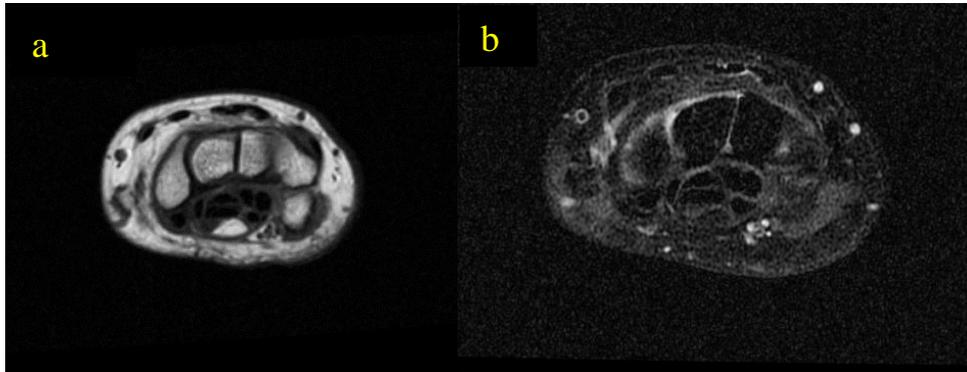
T1-weighted axial MRI image showing an occupying-space lesion with hyperintense in the carpal tunnel (a). T2-weighted axial MRI image showing an occupying-space lesion with hypointense in the carpal tunnel (b).
